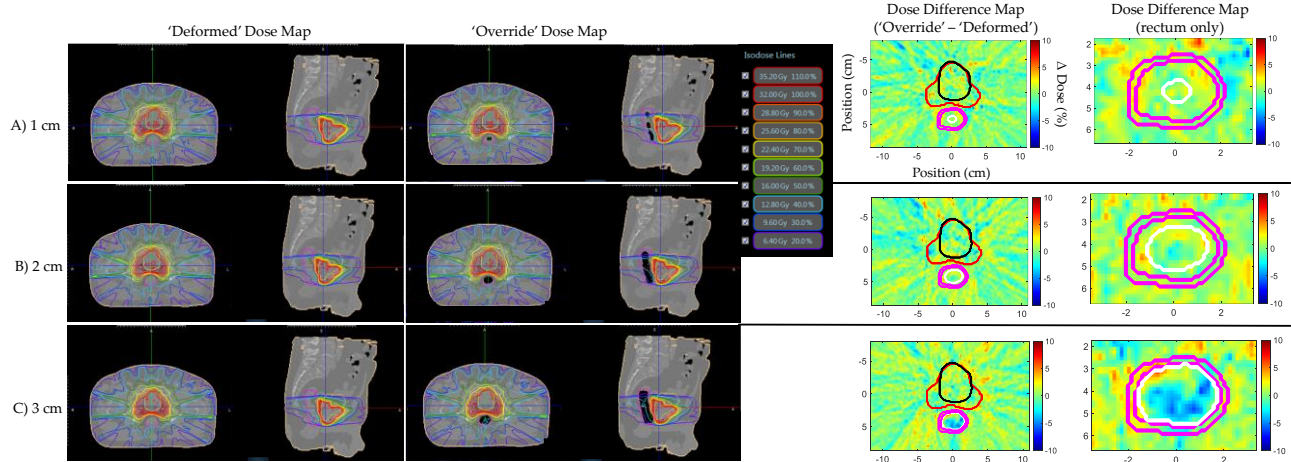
Prostate bed Patient B’s ‘Deformed’ and ‘Override’ plan dose and dose difference maps for (A) 1, (B) 2, and (C) 3 cm artificial daily MRI air cavities. Target/organ mean and max dose difference was relatively small (<4%) despite air cavity correction in the ‘Override’ plan. Dose difference map daily MRI contours displayed: Red—PTV, Black—bladder, Pink—rectum, White—artificial air cavity.
